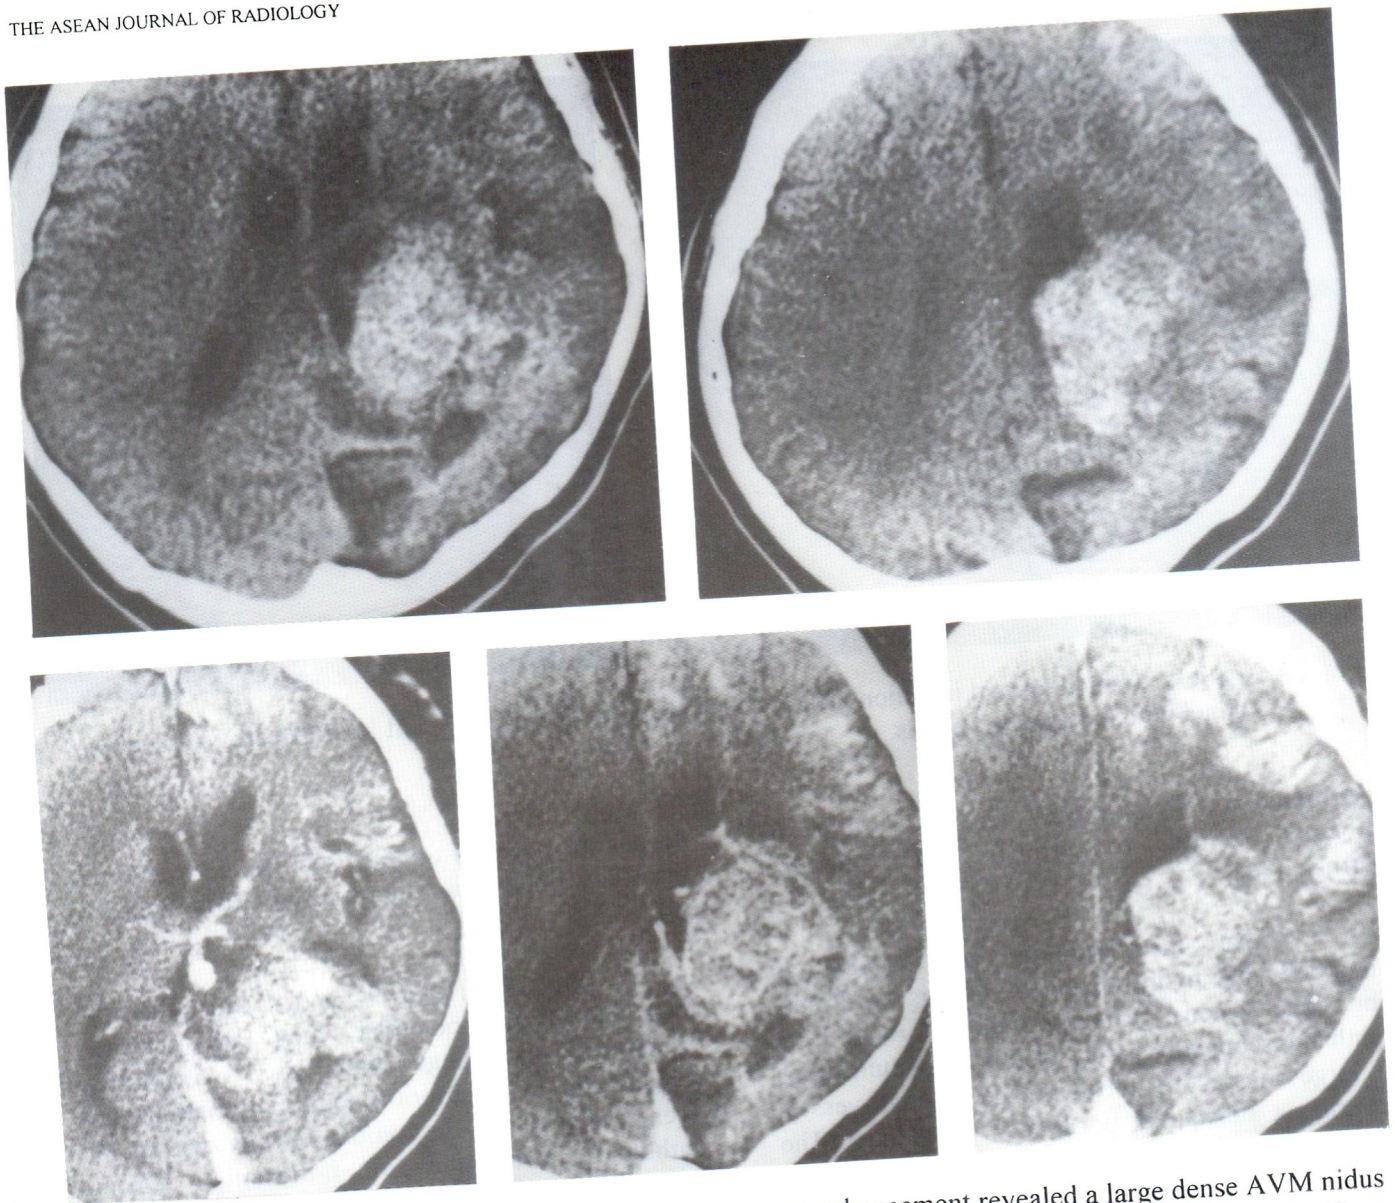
Axial CT scan of the brain with and without contrast enhancement revealed a large dense AVM nidus in the region of left splenium of corpus callosum, and around left posterior horn of left side. Gyriform enhancement of subacute left hemispheric ischemia was noted.
